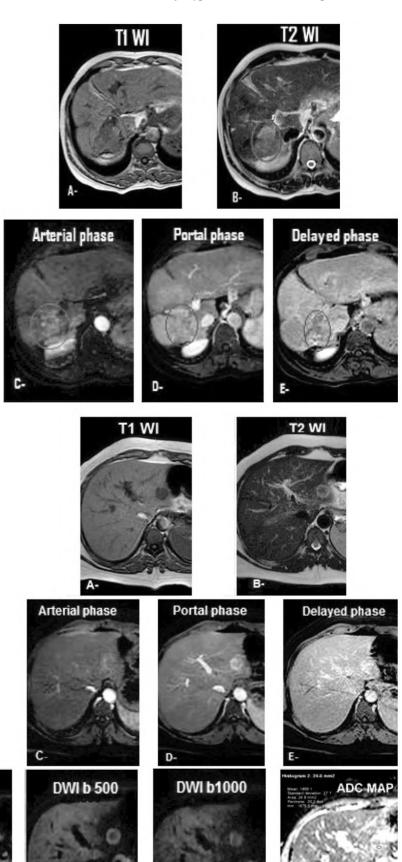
52 year old female patient presented with mild abdominal discomfort. AFP: 7ng/ml. Typical hemangioma. Axial unenhanceded T1 WI (A) and T2WI (B) showed a lesion in the lateral segment of the left hepatic lobe (segment II) of low signal intensity on T1WI and mildly increased signal intensity on T2WI. Axial gadolinium-enhanced arterial-phase image (C), portal phase (D) and delayed venous phase (E), showed peripheral nodular enhancement of the lesion in the arterial phase and gradual filling in in the portal and delayed venous phases. On DWI (b: 0, 500, 1000). (F, G and H) respectively; they showed the lesion to be of decreased signal intensity owing to more likely facilitated diffusion. Axial ADC map (I) showed the lesion to be of high signal intensity and of high ADC value (1.6x10 mm²/sec), proving that the lesion is of benign nature.
